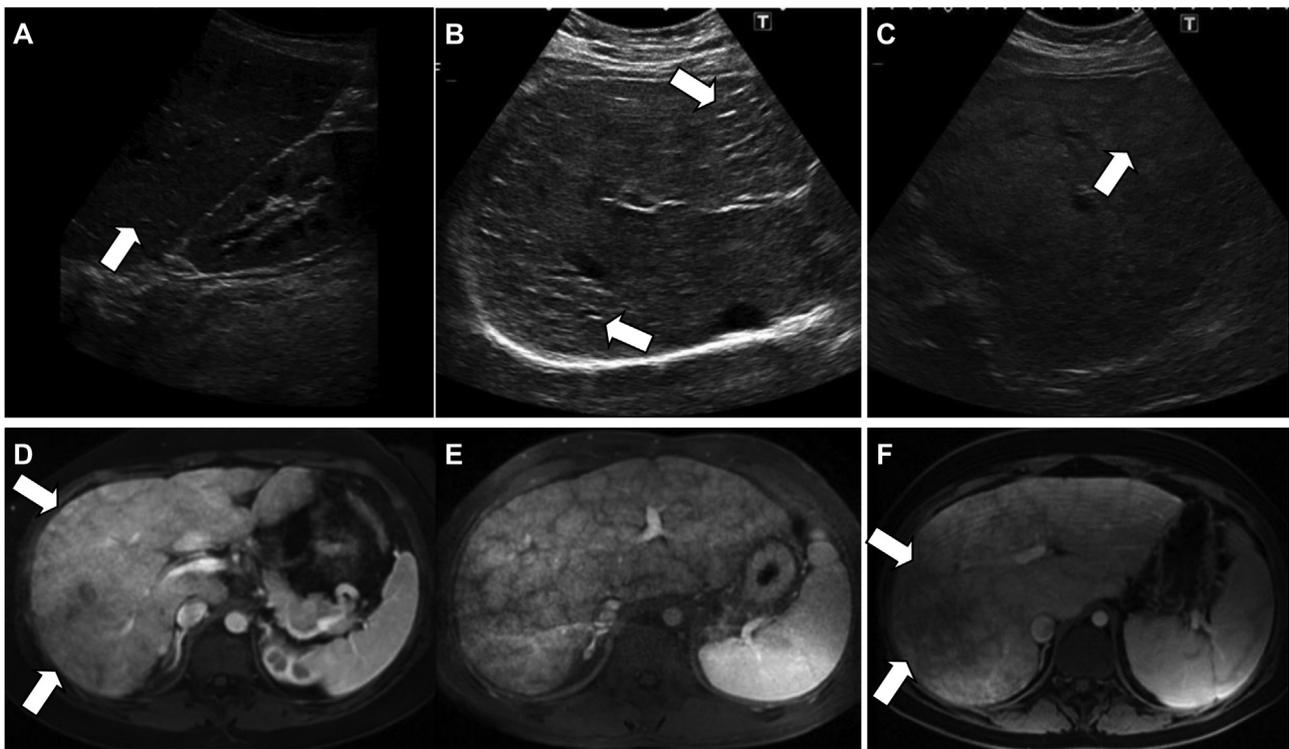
Radiological imaging tracks the progression of liver fibrosis in Fontan-associated liver disease (FALD). Ultrasound shows variable echo-texture in Fontan patients. (A) Ultrasound image of a 5-year-old female with extra-cardiac Fontan showing normal echo-texture. (B) Image of liver from a 16-year-old male, 14 years following an extra-cardiac Fontan with very coarse echo-texture and patchy areas of focally increased echogenicity. (C) Ultrasound image from a 28-year-old female, 24 years after lateral tunnel Fontan with diffusely increased liver echo-texture with nodularity and irregular liver contour, suggestive of liver cirrhosis. Abnormal liver enhancement in FALD. (D) Portal venous phase contrast magnetic resonance image shows relatively mild peripheral reticular enhancement (arrows). (E) Diffuse peripheral and central reticular enhancement pattern is seen in more advanced congestive hepatopathy. (E) Increased congestion with fibrosis is suggested by severe enhancement abnormalities with larger areas of focally diminished enhancement in the right lobe (arrows).
